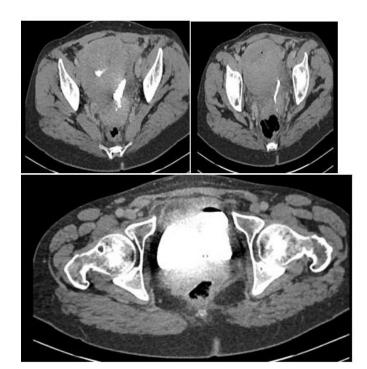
CT scan of a vesicovaginal fistula.
